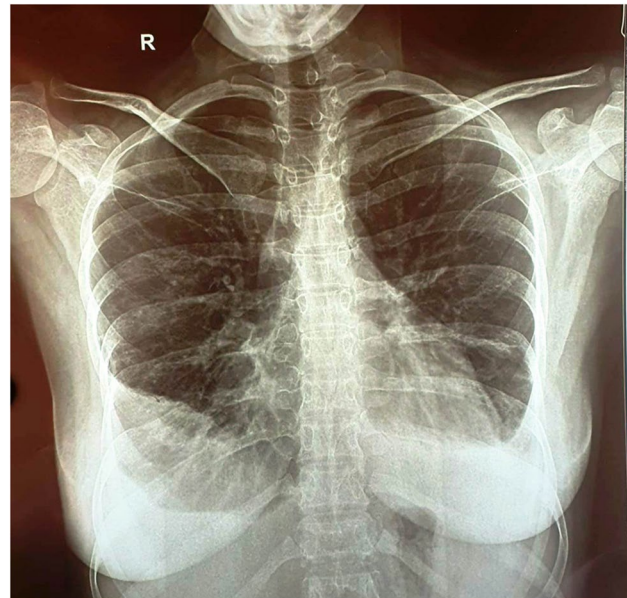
X-ray chest showing bilateral pleural effusion mainly on the right side
